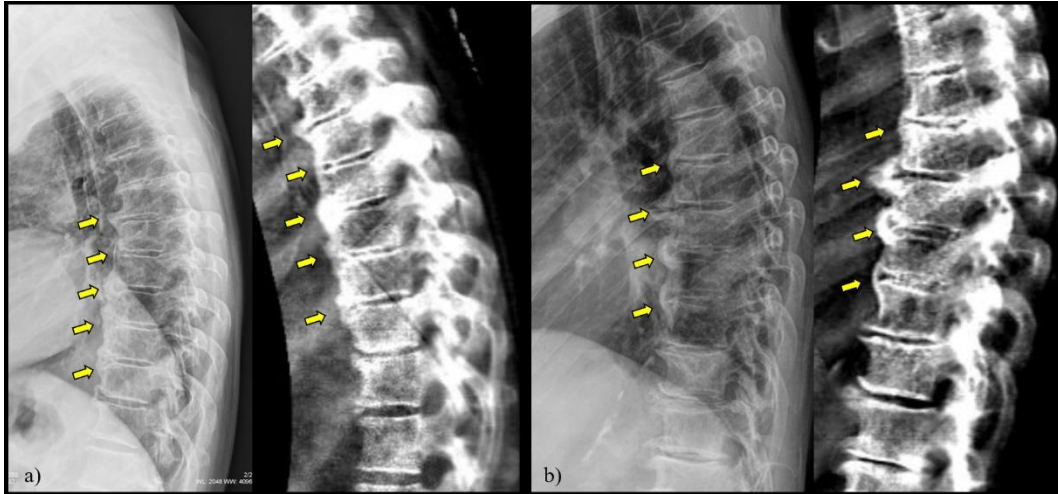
Two cases of DISH as documented by DXA-VFA and respective X-rays in two different type 2 diabetic women (patient A and patient B). X-Rays are reported on the left and VFA on the right, respectively.
